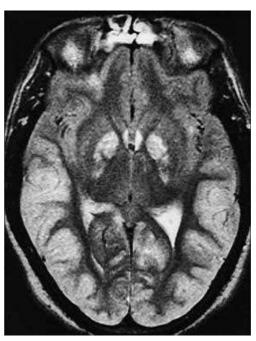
Magnetic resonance imaging of the brain shows areas of infarction following carbon monoxide poisoning. This T2-weighted image shows abnormally high signal intensity in the basal ganglia, right frontal lobe, and cerebral cortex.
